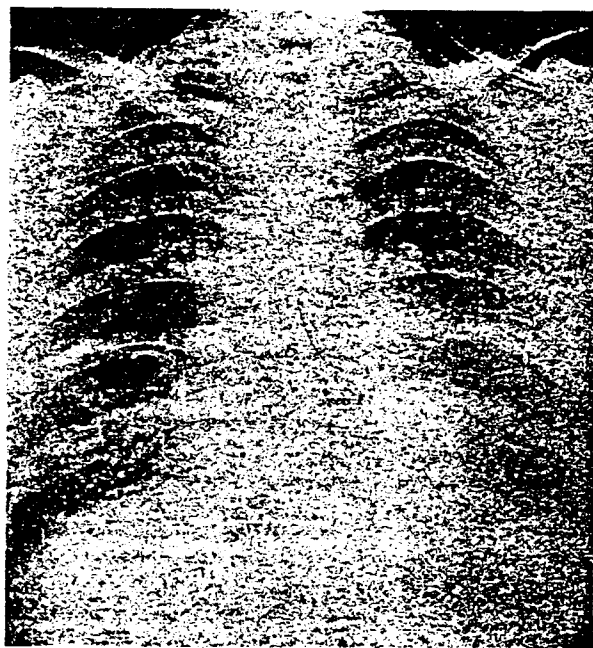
X-ray film of a patient with asbestosis. (Pendergrass.)
